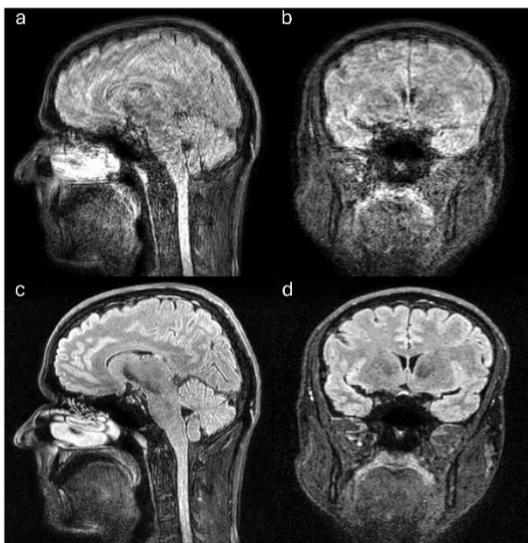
3D T2 FLAIR TSE scan of subject with large pose changes during scan. (a/b) Non-corrected reconstruction. (c/d) RMC reconstruction recovering details, contrast, and SNR.
